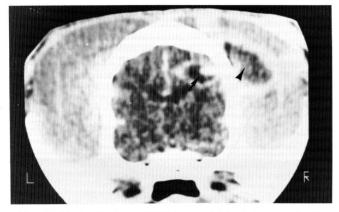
Contrast-enhanced CT image obtained 1 week after hyperthermia treatment (44°C × 30 minutes at r = 0.5 cm from the antenna gap) with a single-gap dipole antenna implanted laterally 2.1 cm from the brain surface to the antenna tip or 1.0 to 1.1 cm from the brain surface to the antenna gap. An ellipsoidal thermal lesion (*arrow*) surrounded by a contrast-enhanced narrow ring was observed in brain. Note the additional low density area (*arrowhead*) surrounded by a thick region of enhancement in the temporalis muscle tissue along the tract of the antenna feed line.
